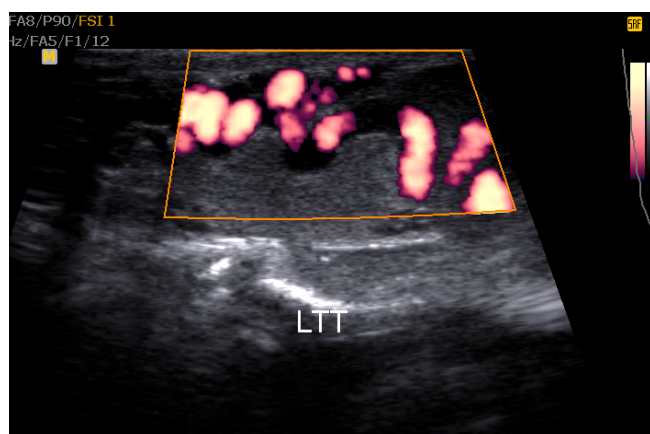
Power Doppler evaluation demonstrating spontaneous venous flow within left-sided intratesticular varicoceles
